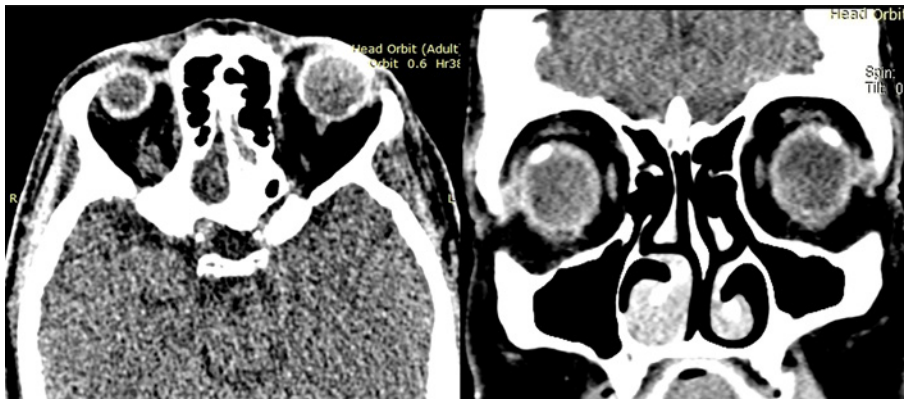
Two different CT scans showed an asymmetrical and irregular calcified lesion in the posterior choroid in both supero-temporal choroids; on the right a transversal scan of the orbits, on the left sagittal scan of the orbits.
